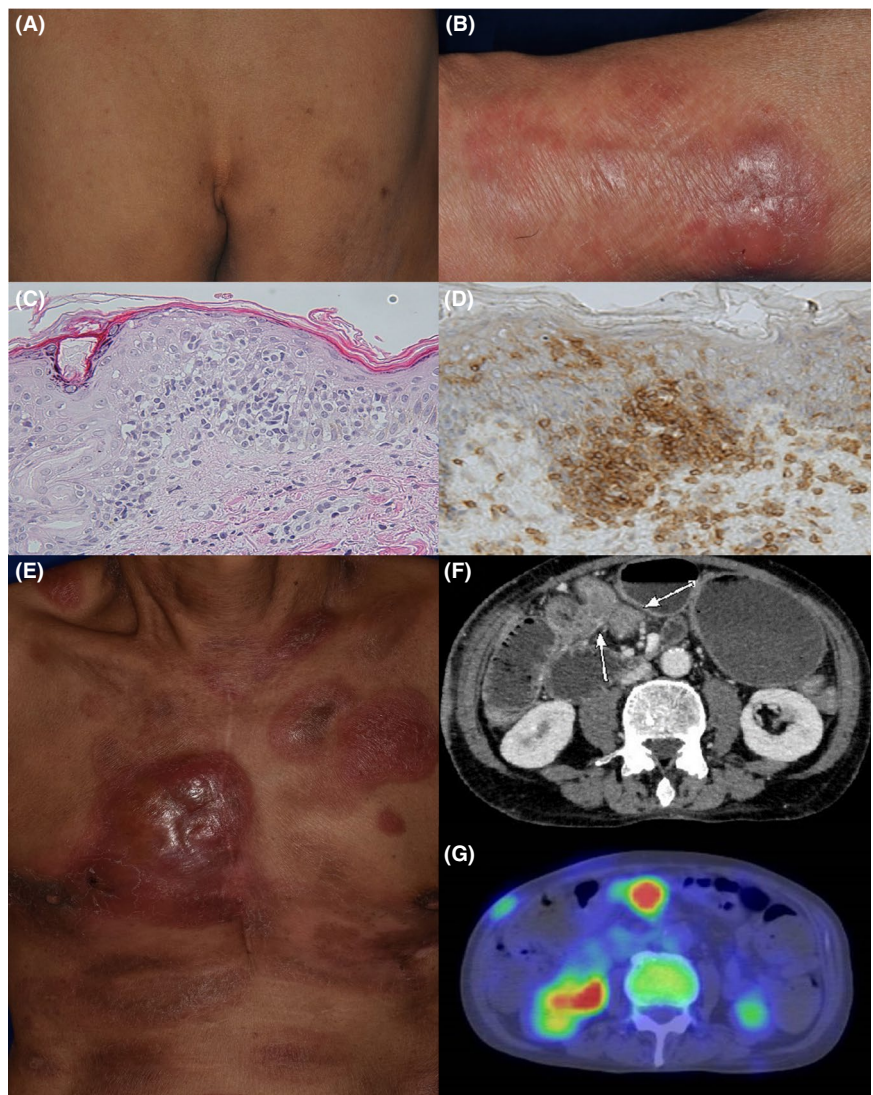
Erythema distributed on the buttocks (A) and the forearm (B). (C) Atypical lymphocyte infiltration into the epidermis (HE × 400). (D) Infiltrating lymphocytes positive for CD4 (×400). (E) Tumors on the trunk seven years after first examination. (F) Computed tomographic scanning showing small intestinal ileus. (G) Abnormal accumulation at the site of small intestines
